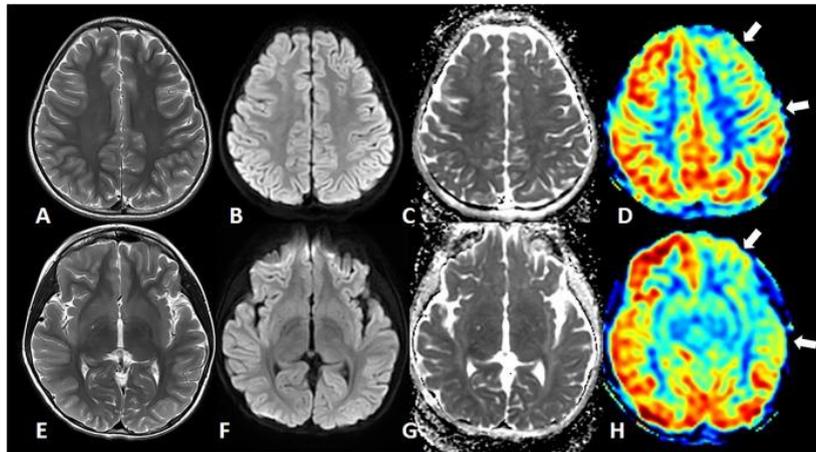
Patient 19: A 7-year-old girl presenting focal impaired awareness seizure (ictal vocalization followed by impaired awareness, right arm dystonia, left eyeball deviation, and left head deviation). Her interictal EEG result was normal. Axial T2-weighted images (A, E), diffusion weighted images (B, F), and apparent diffusion coefficient images (C, G) show no abnormal focal lesion in the brain parenchyma. ASL perfusion MR images (D, H) depict a hypoperfusion in the left fronto-temporal lobes (arrows). In this patient, clinical seizure focus was in the left frontal area. (39)
